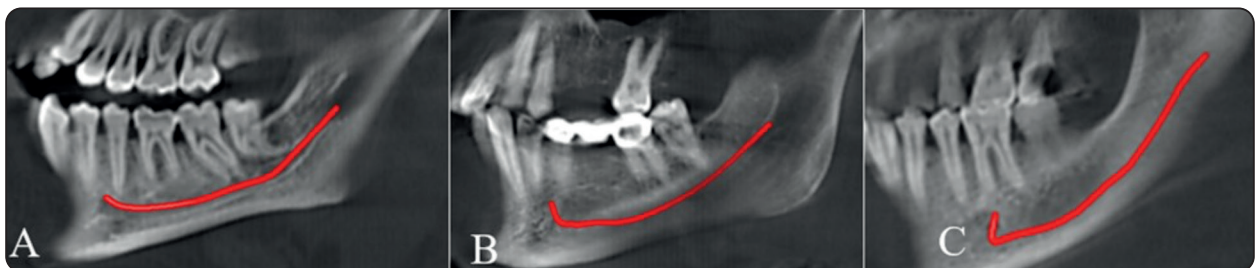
CBCT, sagittal views showing the mandibular canal (MC) path by tracing the inferior alveolar nerve (IAN). A: Linear path, B: Vertical path, and C: Anterior loop (AL).
